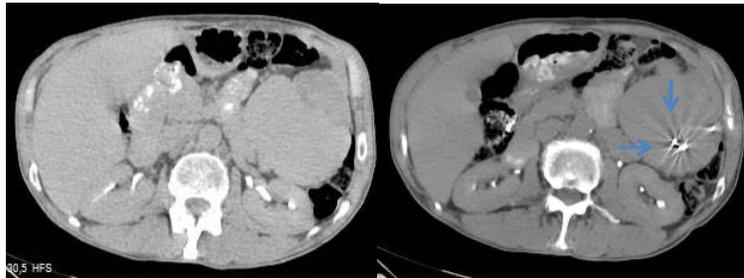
There seemed 3*3 cm of an encapsulated resorbed hematoma collection above the spleen. It was significantly regressed when compared to the previous CT.
